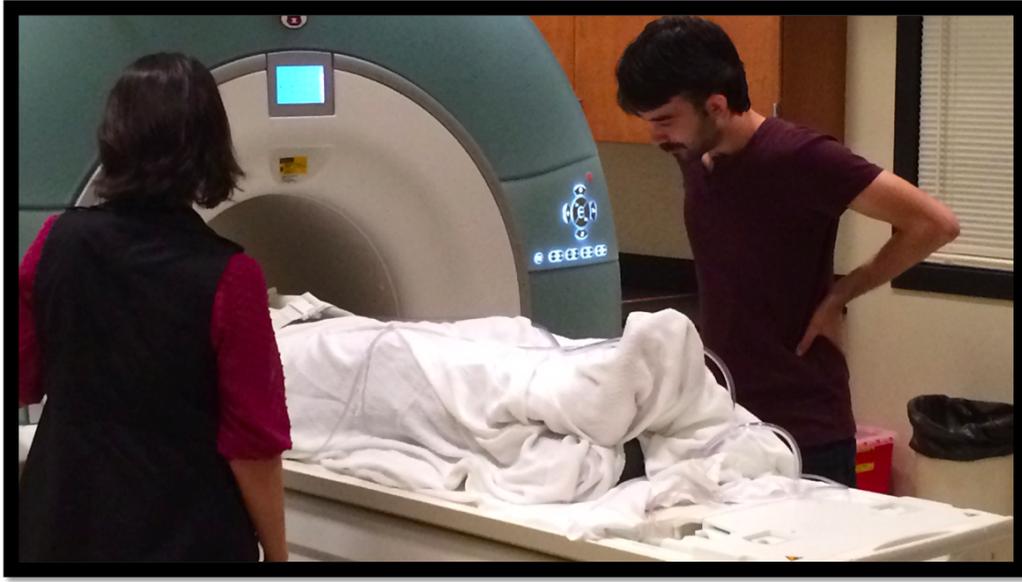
Participant Entering MRI Scanner
